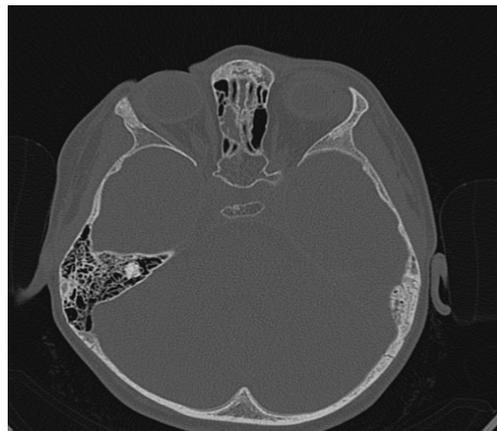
CT scan- bone window, showing asymmetry of the ethmoidal bone
